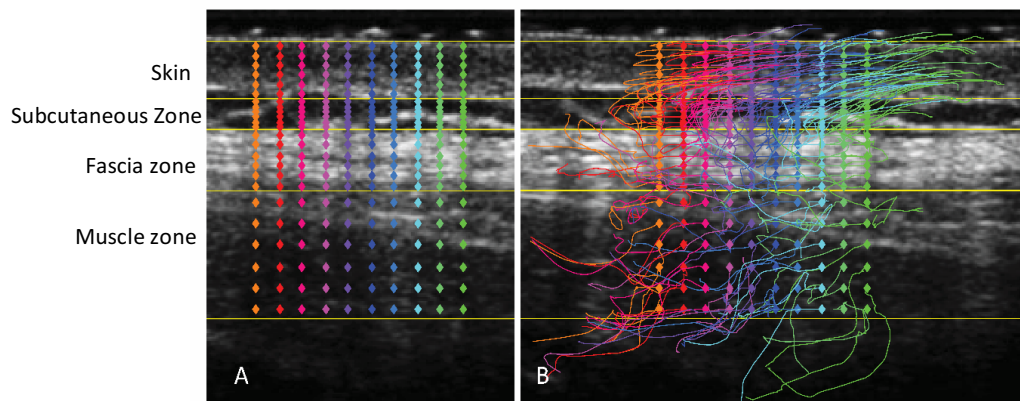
Demonstration of ultrasound tracking result.
